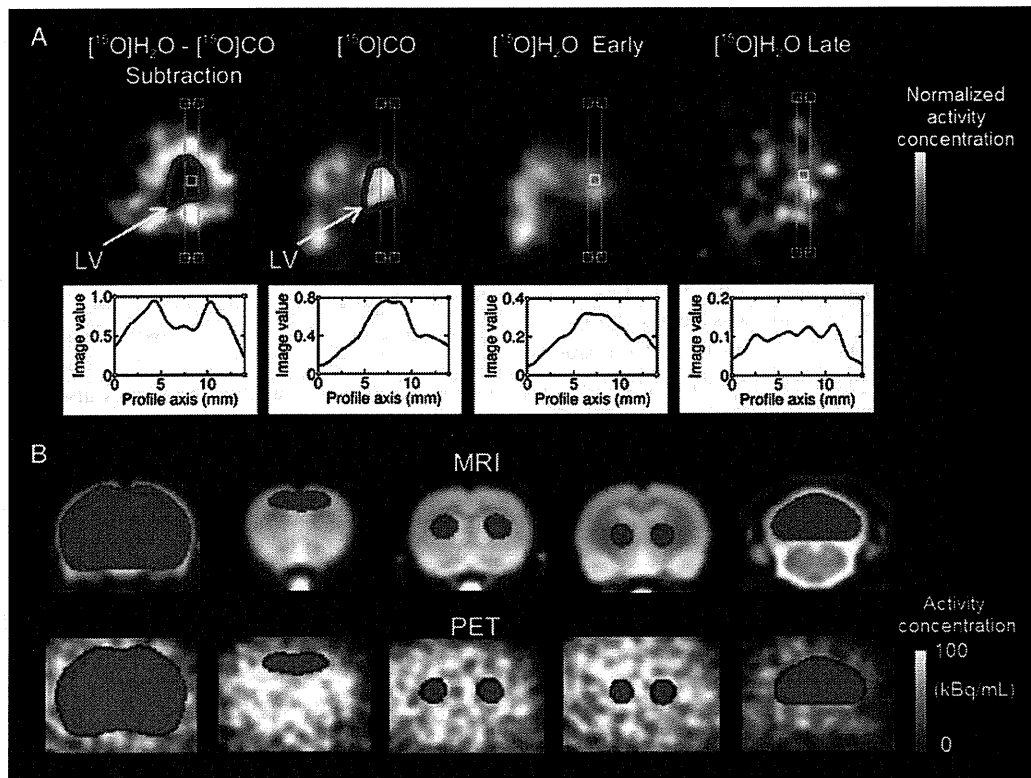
VOIs. (A) VOI in the cardiac ventricle (delineated by red line). The VOI, delineated manually using the subtraction image of $[^{15}\text{O}]\text{H}_2\text{O}$ minus $[^{15}\text{O}]\text{CO}$ activity concentration (upper left), is transferred to the sum image of $[^{15}\text{O}]\text{CO}$ $[^{15}\text{O}]\text{H}_2\text{O}$ in the early phase (0–30 s) and $[^{15}\text{O}]\text{H}_2\text{O}$ in the late phase (150–180 s). Lower graphs show the profile of activity concentration on the line that is crossing the center of cardiac ventricle (as shown in light blue overlaid on the upper PET image). The image value in the graphs is in units of MBq/ml. Each PET image is shown in a gray color bar in an arbitrary range. (B) The coronal sections of MRI (upper) and PET images (lower) on which cerebral VOIs are overlaid in red. The furthest left section shows the whole-brain VOI. From the second left to right, the distance of each coronal slices was 2, 0, -2.6 and -12.0 mm from the bregma, each depicting the VOIs in the frontal cortex, striatum, thalamus and cerebellum, respectively. Each PET image was obtained by averaging dynamic PET images from 0 to 3 min. The activity concentration shown ranged from 0 to 100 kBq/ml as indicated in the gray color bar.
